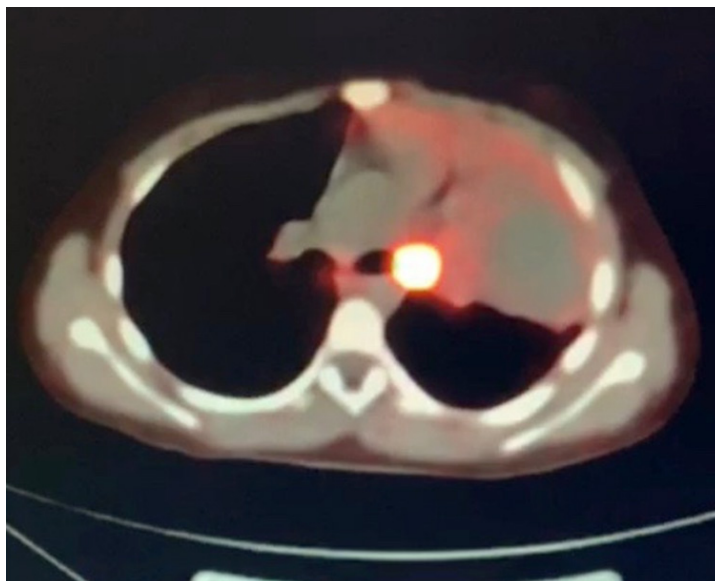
68Ga DOTATATE PET-CT shows high uptake in a left main bronchus mass
